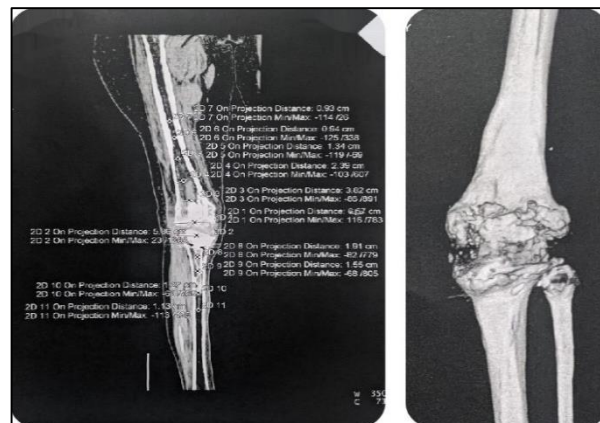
Computed tomography scan for assessment of canal diameter.
